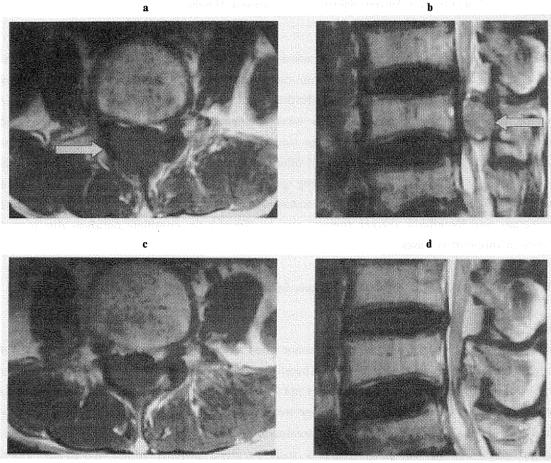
MR images of the lumbar spine. a, b) pretreatment; the tumor at the 4th lumbar vertebral arch (arrow) is seen with compression of the dural sac. c, d) the tumor markedly diminishes in size four months after the end of treatment.
